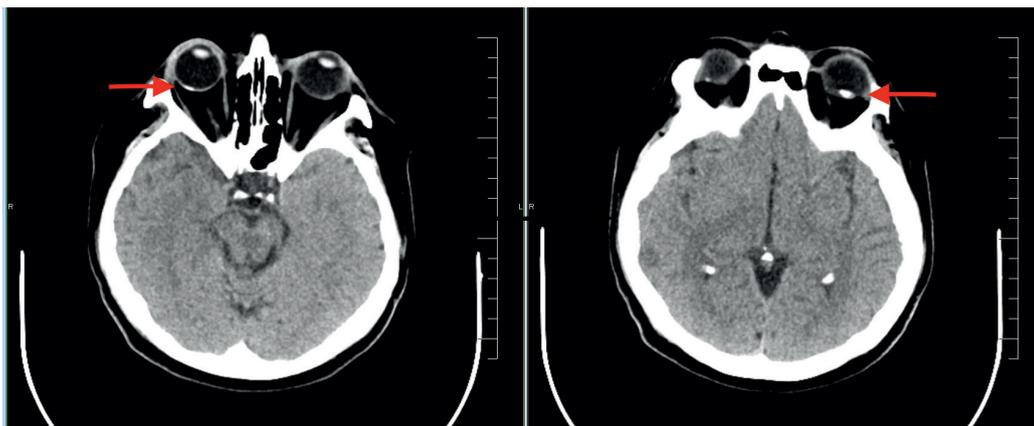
Brain CT scan – arrows indicate bilateral sclerochoroidal calcifications
